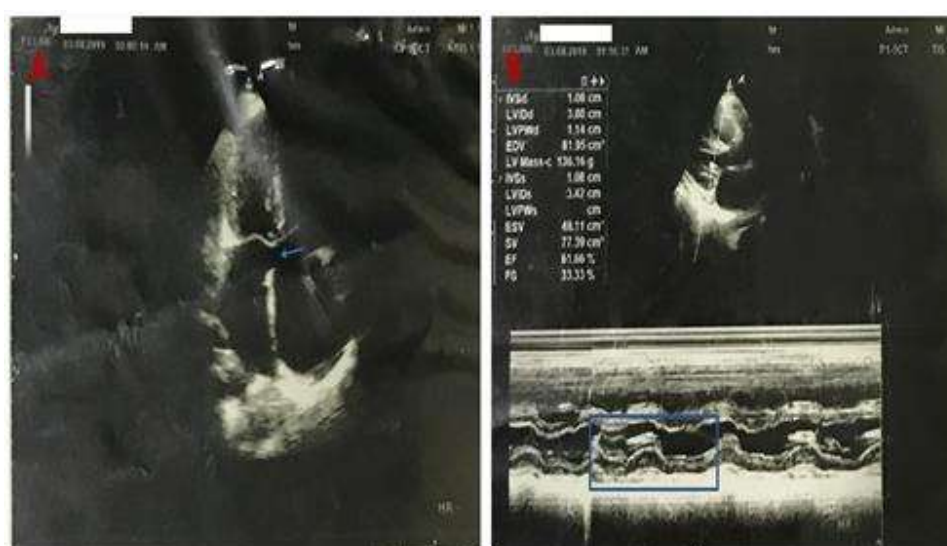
Apical four chamber view showing large ASD primum (line arrow). (A) parasternal long axis view with M-mode showing abnormal movement of mitral valve leaflets and inadequate coaptation (selected area in B).
